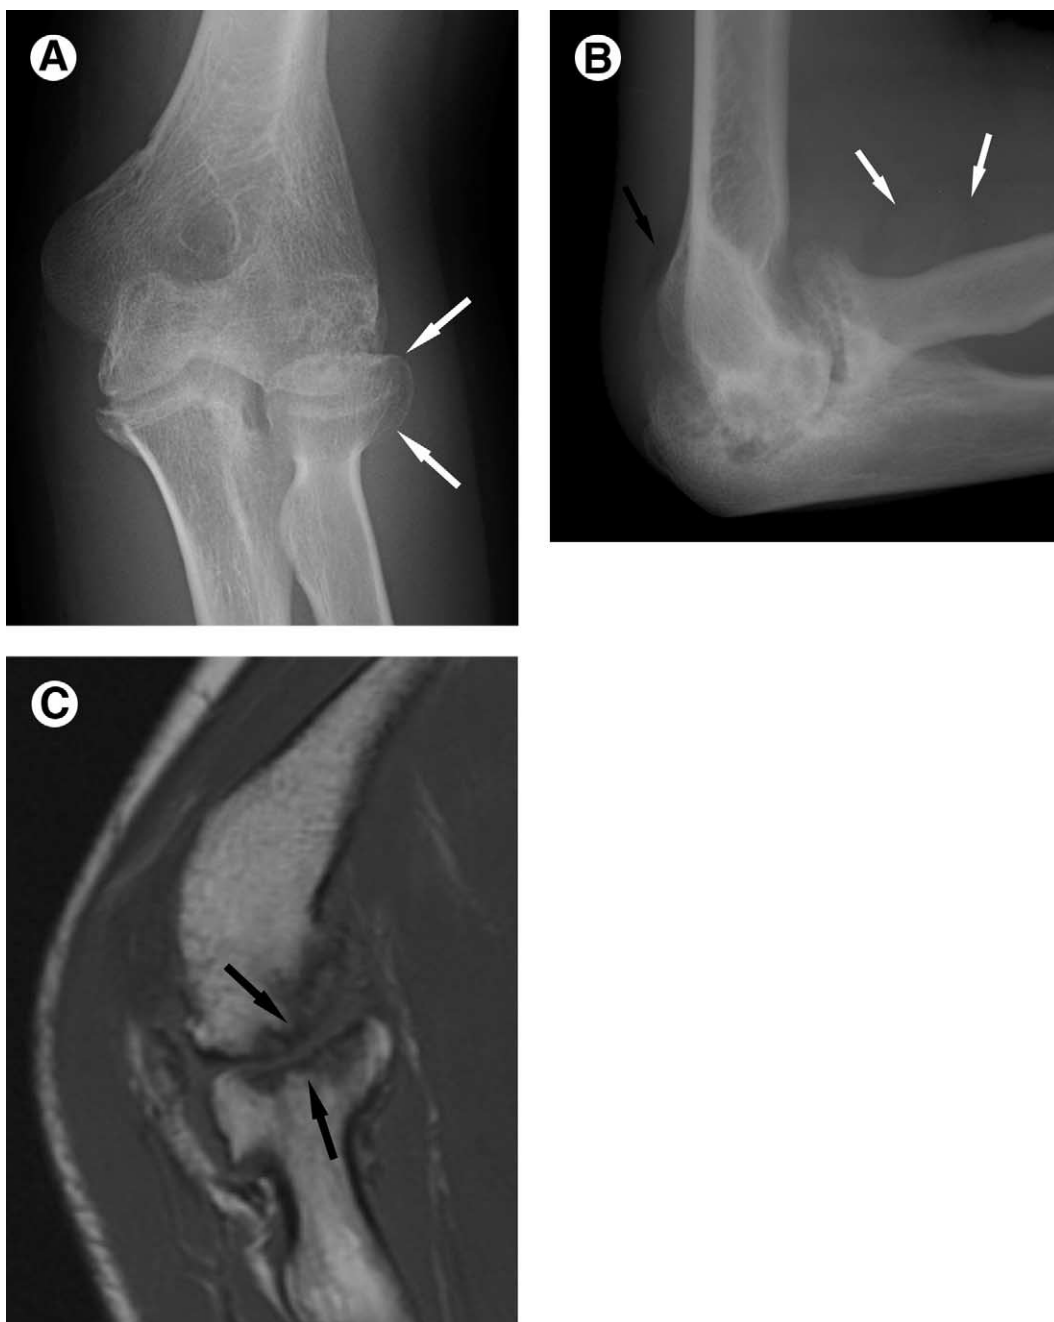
Hemophilia. (A) Anteroposterior view in young person demonstrates overgrowth of radial head (arrows) and early irregularity of ulnotrochlear and radiocapitellar joint surfaces. (B) Lateral radiograph in same patient, 2 years later, reveals more advanced destruction of articular surfaces and formation of subarticular cysts. There is a positive posterior fat pad sign (black arrow) and dense joint effusion with distension of periradial recess (white arrows), suggesting hemarthrosis. (C) Sagittal T1-weighted MR image shows complete loss of cartilage along radiocapitellar joint with irregular sclerosis of subarticular trabecular bone (arrows).
